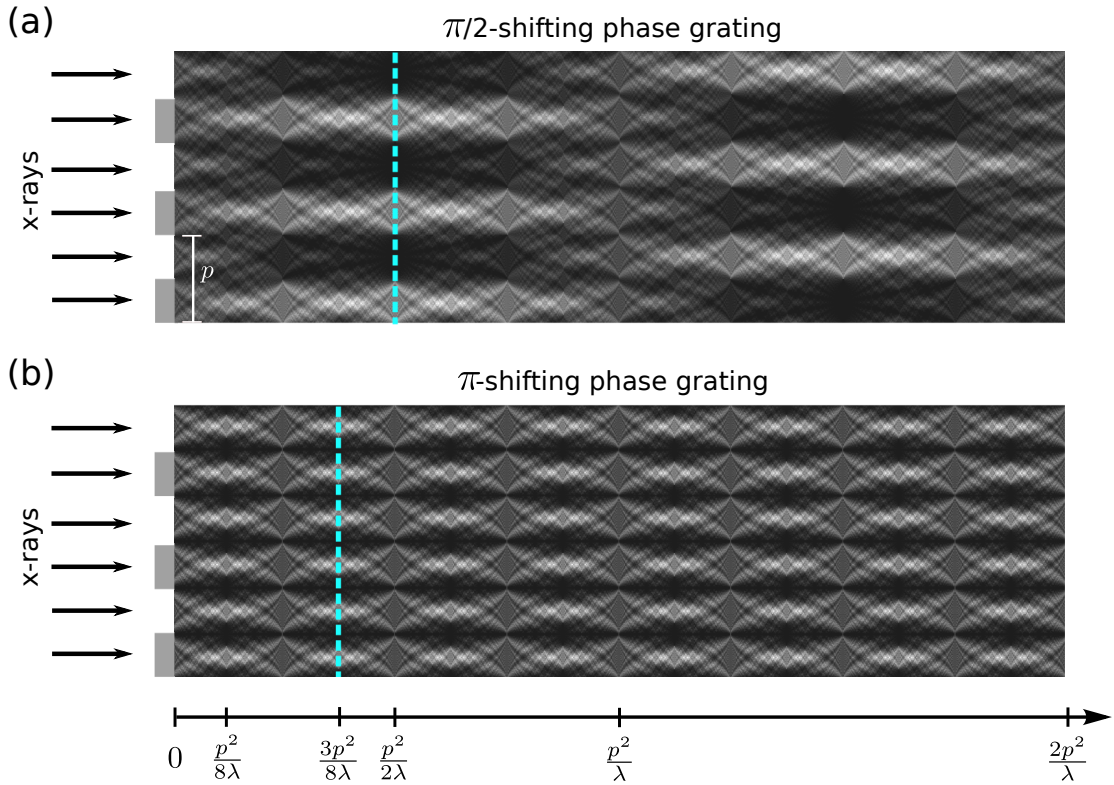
X-ray intensity patterns created by a plane x-ray wavefront that was propagated through a $\pi/2$ -shifting (a) and a π -shifting (b) phase grating. For each intensity pattern two exemplary fractional Talbot distances are marked by a dashed line, at which the intensity pattern is box shaped. The propagation is plotted up to the first full Talbot distance. Figure adapted from Tapfer (2013).
